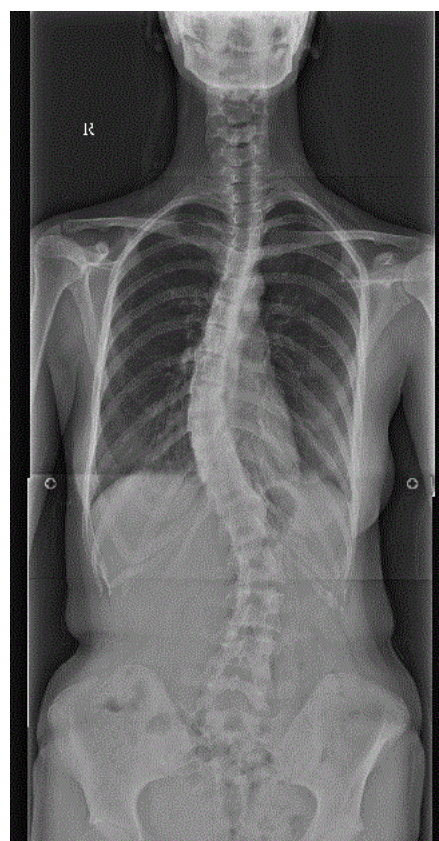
Spine antero-posterior (AP) X-ray showing severe scoliosis of the thoracic spine (lateral convexity to right side) and lumbar spine (lateral convexity to left side). Using the Cobb technique, the Lippman-Cobb's angle was 42° of the thoracic curve (T5-T12) and 43° of the lumbar curve (T12-L4).
